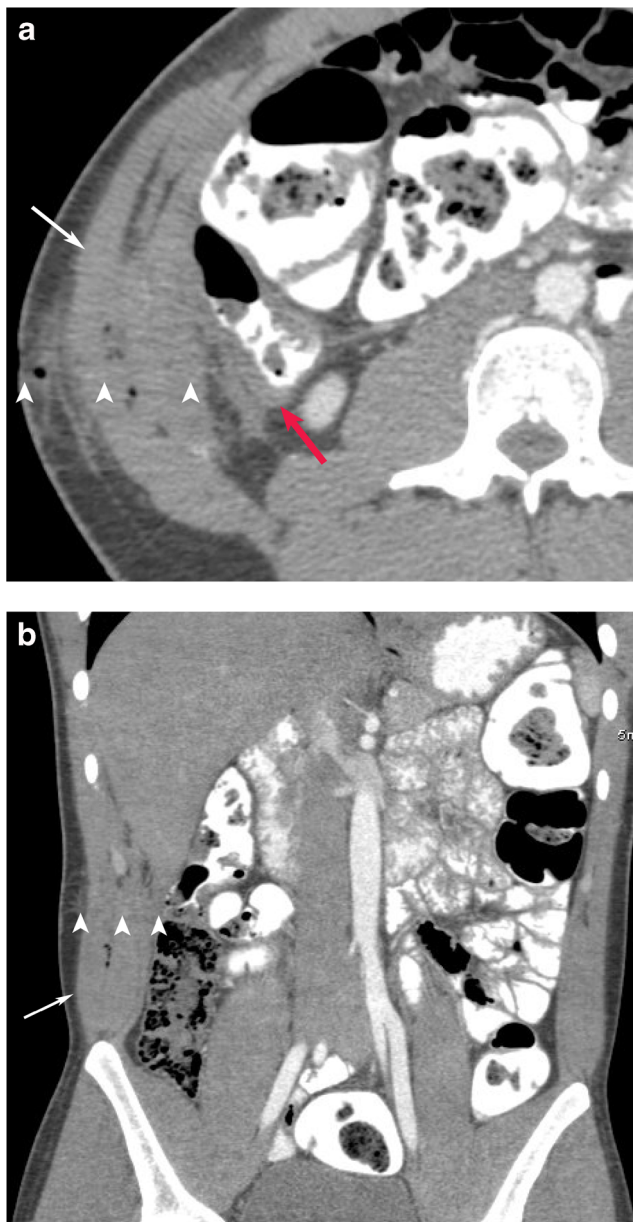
Stab wound to right flank demonstrating wound tract extending up to bowel. a. Axial and b. Coronal reformat CT images demonstrate a wound tract (arrowheads) outlined by hematoma, gas bubbles extending from the skin up to proximal ascending colon. Colonic wall thickening (red arrow) and an abdominal muscle hematoma (white arrows) is also seen. At surgery a full thickness ascending colon injury was repaired
